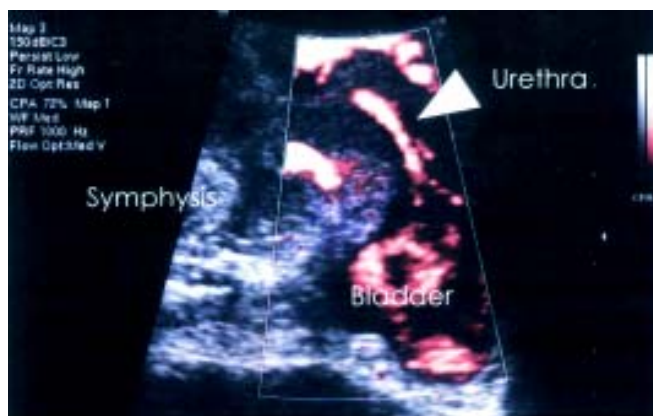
CD Energy (CDE) imaging in Genuine Stress Incontinence. The Doppler signal outlines most of the proximal urethra (arrows).
